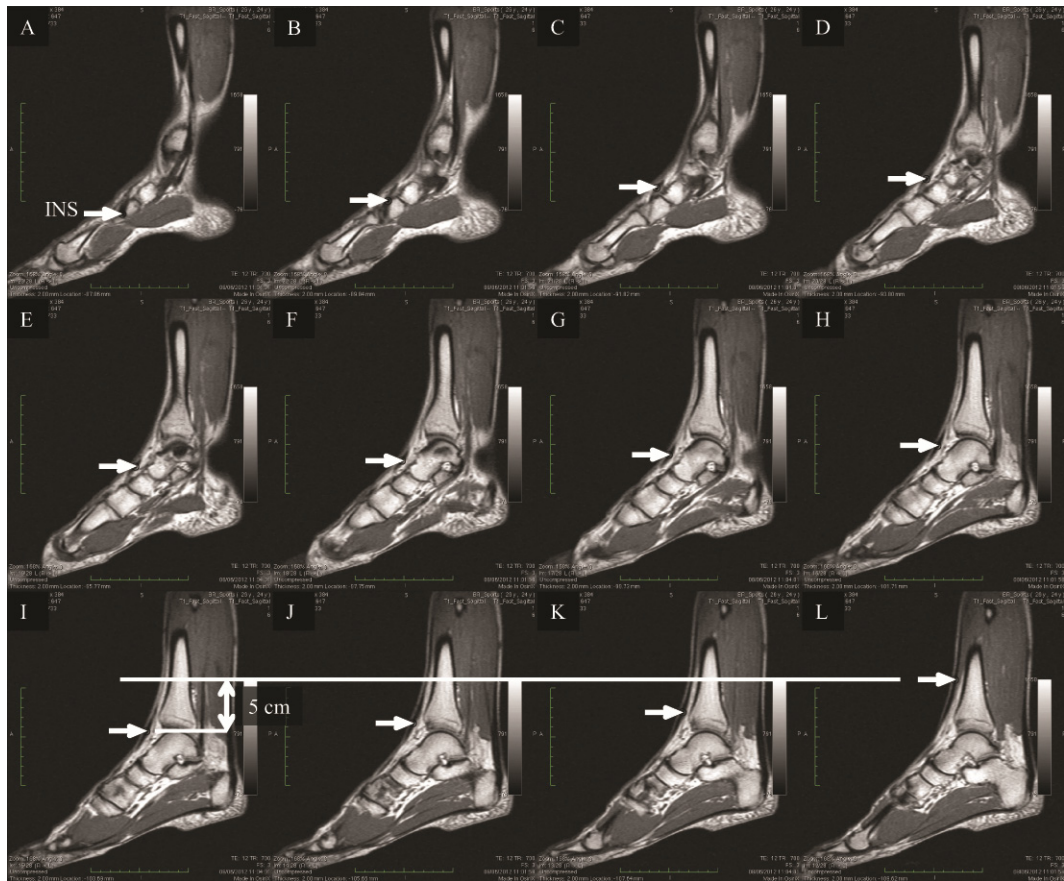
The tibialis anterior tendon was tracked (centroid of each tendon slice indicated by white arrow) from the most distal insertion point (INS: image A) on the medial cuneiform to 5 cm proximal (image L) to the distal head of the tibia. The point on the tibia head was located in the MRI slice (image I) in which the TA tendon passed anterior to the tibia head. The change in length of the tendon across successive foot rotations (45, 30, 15, 0 and \sim 15° plantar flexion) was used as the change in MTU length due to foot rotation. The change in MTJ position (see Fig. 3.1) was subtracted from the change in MTU length due to foot rotation to calculate tendon length change.
